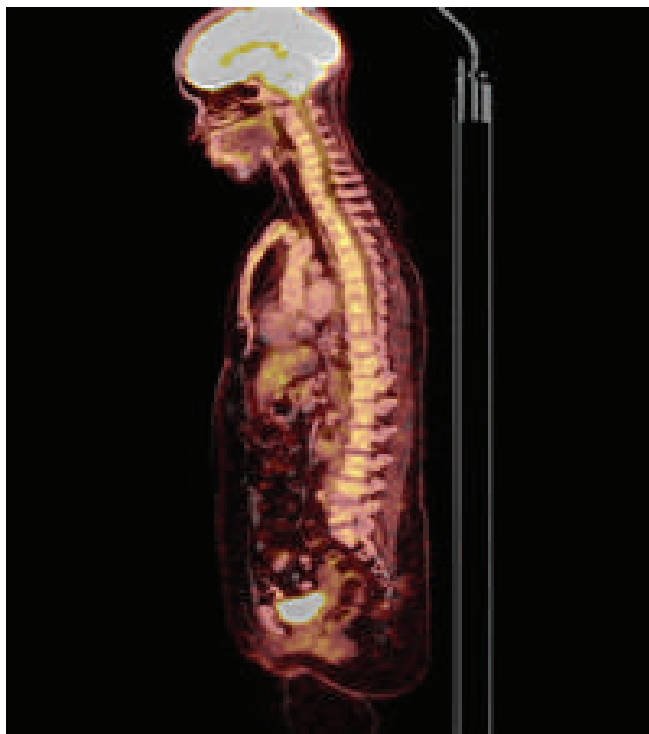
A 35 years woman of left breast carcinoma followed by chemotherapy 2 months ago, came for follow-up PET-CT and sagittal image shows bone marrow hyperplasia due to chemotherapeutic agent.
